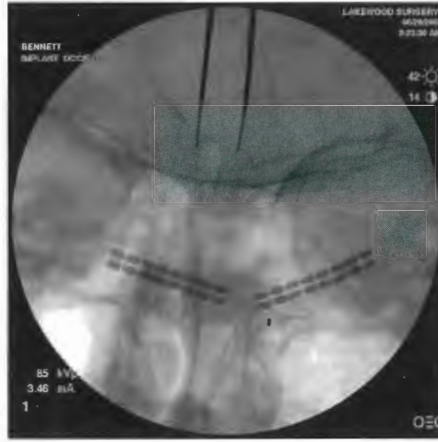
Radiograph of bilateral paddle placement for ONS.
